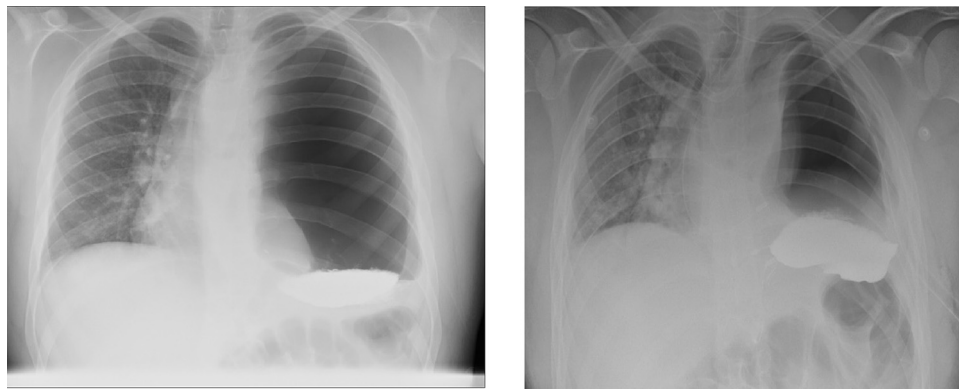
Chest x-ray at initial presentation (left) and post left intercostal catheter insertion (right).
